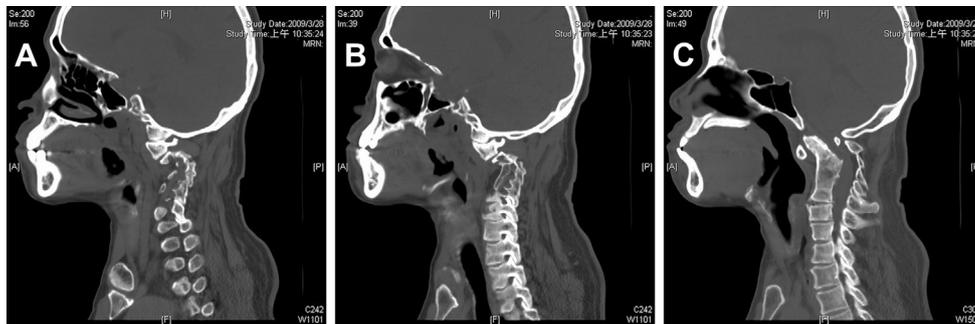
(A, B, and C) Sagittal CT scans showing superior odontoid migration without occipitalization. Angular motion has caused an increase in the atlantodens interval, indicating instability.
